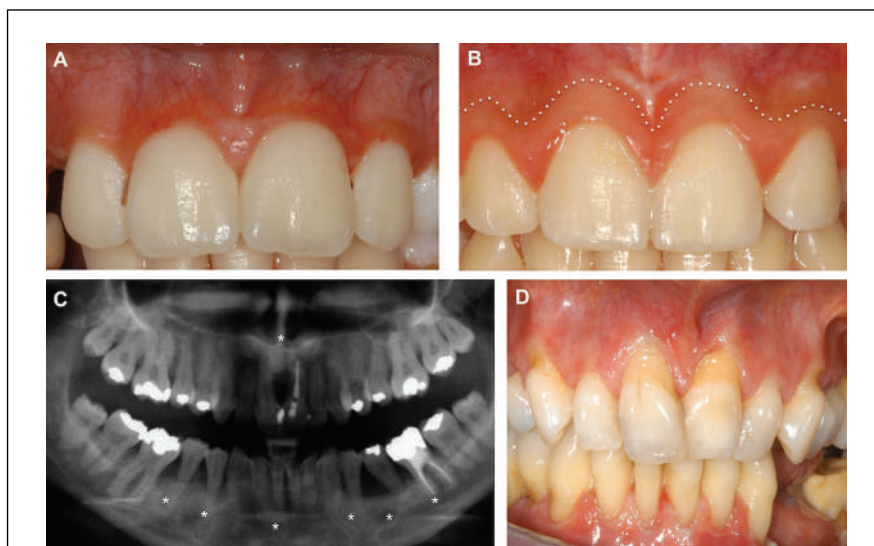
(A) Gingival tissues of a child affected with pEDS. The keratinized gingiva is missing; the oral mucosa extends to the free gingival margin and the interdental papillae and is very fragile. (B) Gingival tissues of a non-affected child. The gingiva is keratinized and is tightly bound to the underlying periostum via collagen structures, and performs a protective function during mastication. The border between gingiva and alveolar mucosa is the mucogingival junction (dotted line). The oral mucosa is non-keratinized and only loosely connected to the periostum; therefore, it is more fragile. (C) Dental radiograph of an affected individual, at aged 29. Notice severe periodontal bone loss (asterisks). (D) Clinical picture of the same individual, at age 30. Premolars in the left mandible have been lost in the meantime without periodontal pocketing and despite good oral hygiene. Notice the lack of keratinized gingiva and gingival recessions (receding gums) (Images kindly provided by Dr. Ines Kapferer-Seebacher, with permission).
